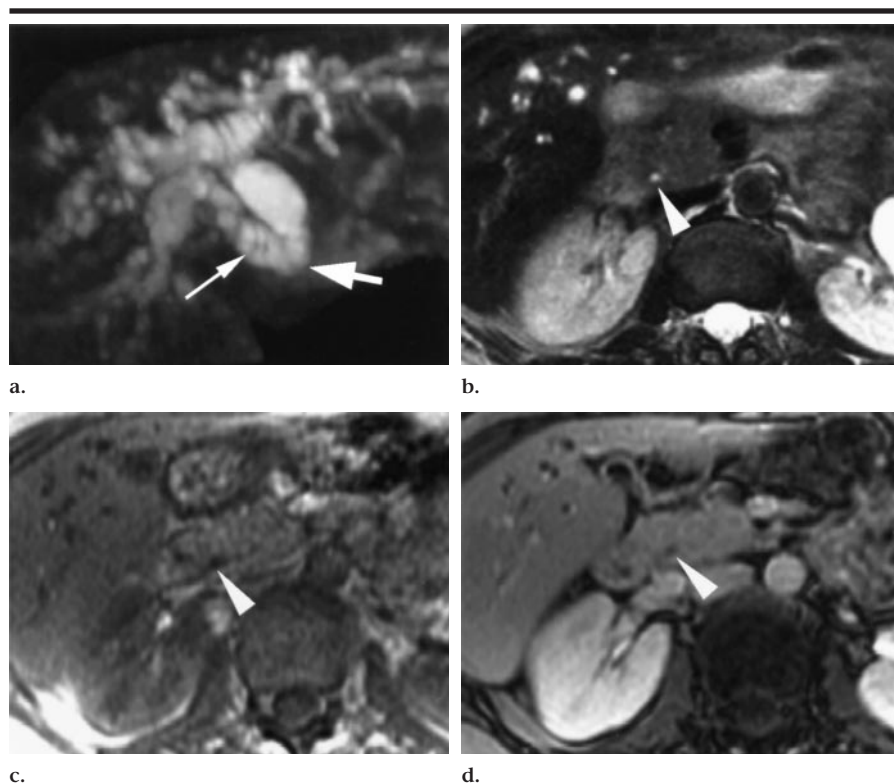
Clinically suspected primary sclerosing cholangitis in a 57-year-old woman with a history of Crohn disease. (a) Coronal maximum intensity projection image reconstructed from heavily T2-weighted MRCP images (fast SE, 12,000/255) shows an abrupt obstruction of the distal common bile duct (thick arrow). A malignant cause was suggested on MRCP images alone for both readers. Extrahepatic insertion of the right posterior hepatic bile duct (thin arrow) into the lower portion of the distal common bile duct is visible. (b) Transverse less heavily T2-weighted image (fast SE, 9,000/144), (c) transverse in-phase GRE image (130/4.2) obtained before the administration of contrast material, and (d) transverse opposed-phase GRE image (130/1.8) obtained after the administration of contrast material show a small, patent distal common duct (arrowhead) and a normal appearance of the surrounding pancreatic parenchyma. Malignancy was excluded correctly with less heavily T2- and T1-weighted images, and the confidence was correctly increased with the postcontrast images for one reader. Ampullary biopsy performed at ERCP showed nonspecific inflammation.
